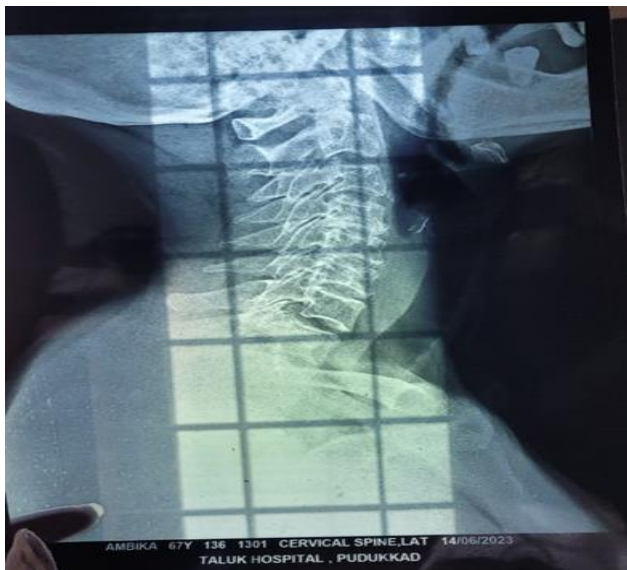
X-ray cervical spine.
